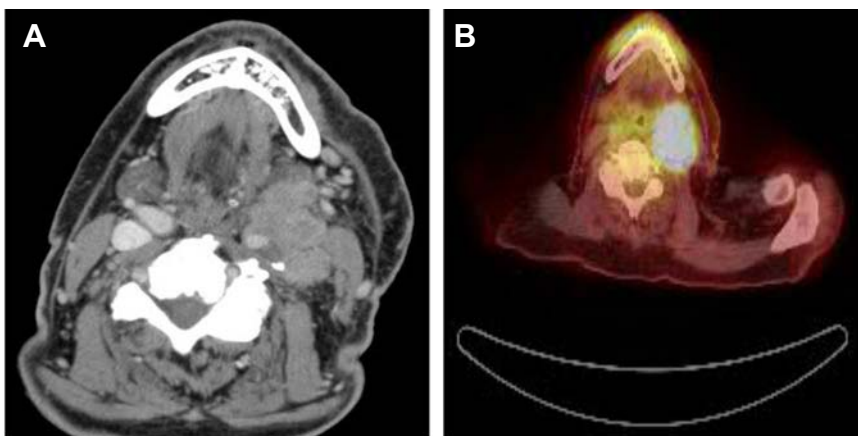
Positron emission tomography/computed tomography (PET/CT). February 2014: A) Image shows right sided tumor completely encasing the common carotid artery, thus making this tumor unresectable; B) Image shows PET/CT scan with hypermetabolic activity. Also shown is the enlarged large level II nodal mass in the left neck.
